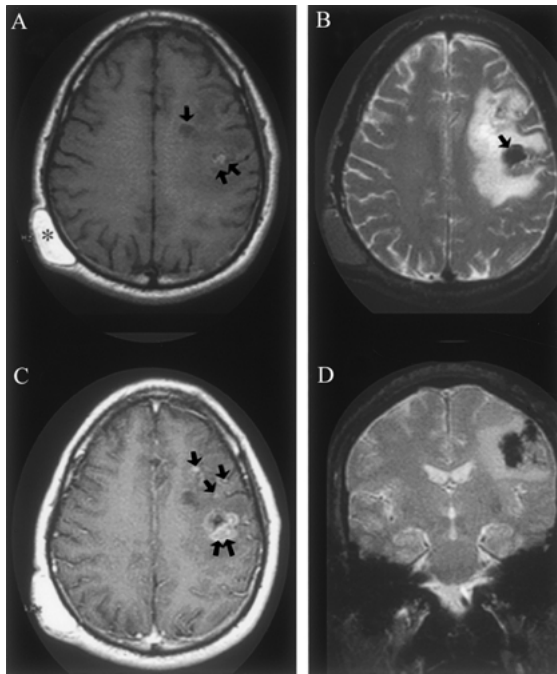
(A) An axial T1-weighted image (TR 600/TE min) demonstrates parenchymal subcortical hypointensity and sulcal effacement in the left frontal lobe, consistent with vasogenic edema. A more focal hypointensity medially (arrow) likely represents cyst formation, while a focal hyperintensity (double arrow) suggests the presence of subacute blood. A right parietal scalp mass (asterisk) with signal characteristics that parallel fat represents an incidental lipoma. (B) An axial T2-weighted image (TR 2500/TE 80) demonstrates the vasogenic edema to better advantage. In addition, multiple small foci of hypointensity located anteriorly and a dominant focus of hypointensity (arrow) more posteriorly are consistent with blood products. The areas which show iso- or hypointensity on the T1WI and hypointensity on the T2WI are consistent with deoxyhemoglobin, while the area which is hyperintense on T1WI and hypointense on T2WI is consistent with extracellular methemoglobin. (C) An axial post-gadolinium T1-weighted image demonstrates irregular foci of enhancement located anteriorly within the left frontal lobe (arrows), and a dominant enhancing mass located more posteriorly (double arrow). The multiple irregular foci of enhancement and dominant mass suggest an underlying neoplastic process rather than the enhancement that can be associated with a subacute hematoma. (D) A coronal multiplanar gradient-refocused image (TR 787/TE 25/flip angle 20) shows multiple regions of very low signal due to magnetic susceptibility effects caused by the presence of blood products. The zone of surrounding vasogenic edema is again seen as surrounding high signal intensity.
